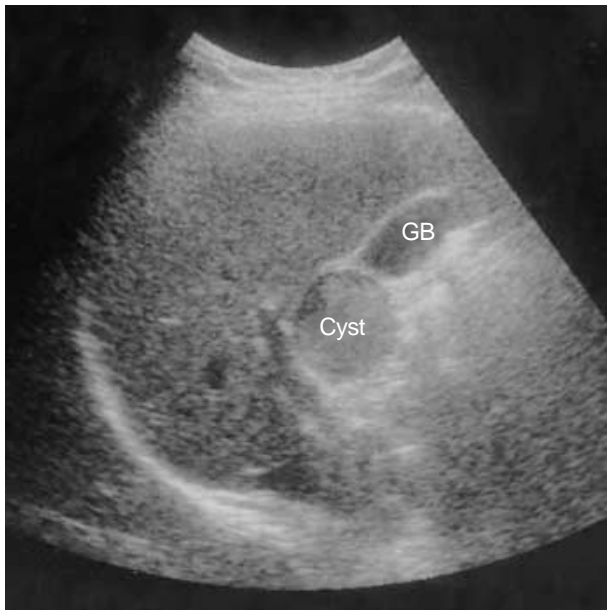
Sonographic finding showing a well-defined round cystic mass adjacent to the gallbladder, the lesion is filled with echogenic materials.
